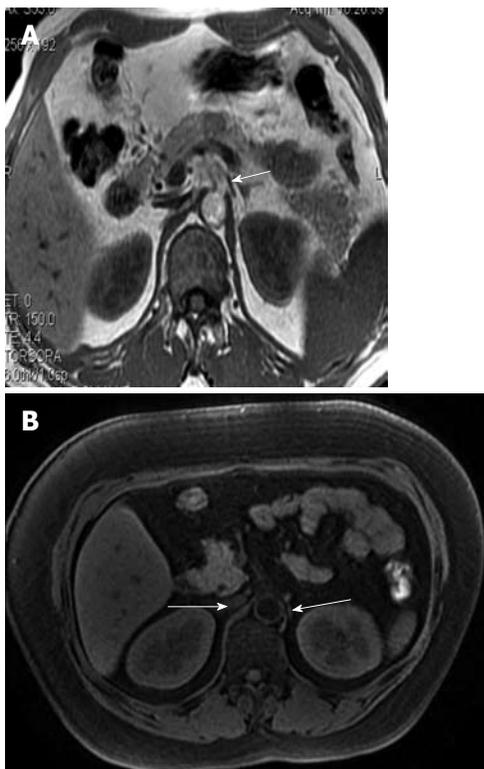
The magnetic resonance imagings of normal adults clearly show the celiac ganglia (A, B). Both celiac ganglia were seen at the level between the celiac artery and the superior mesenteric artery (arrows).
